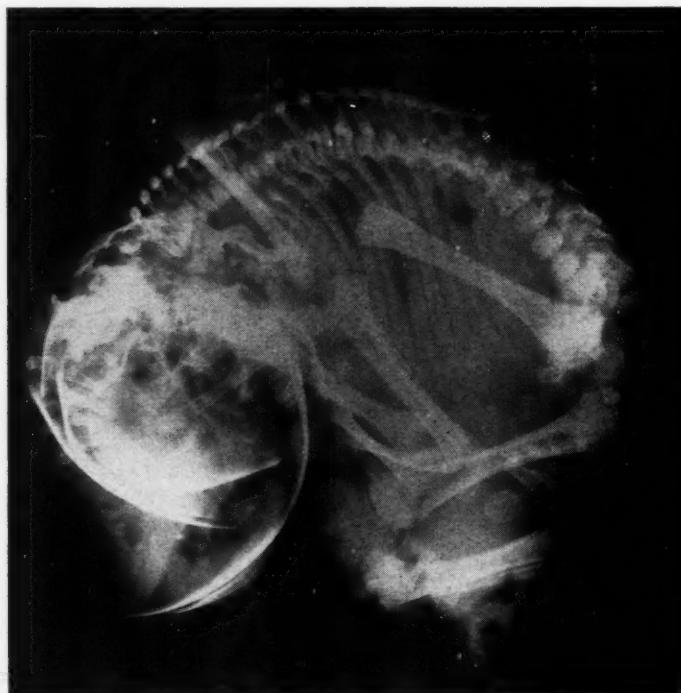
X-ray film of extrauterine fetal sac with its contents after removal. Note the exaggerated Spalding sign as well as the "ball" sign, also the diffuse spread of calcification throughout the body but not in the wall of the sac.
